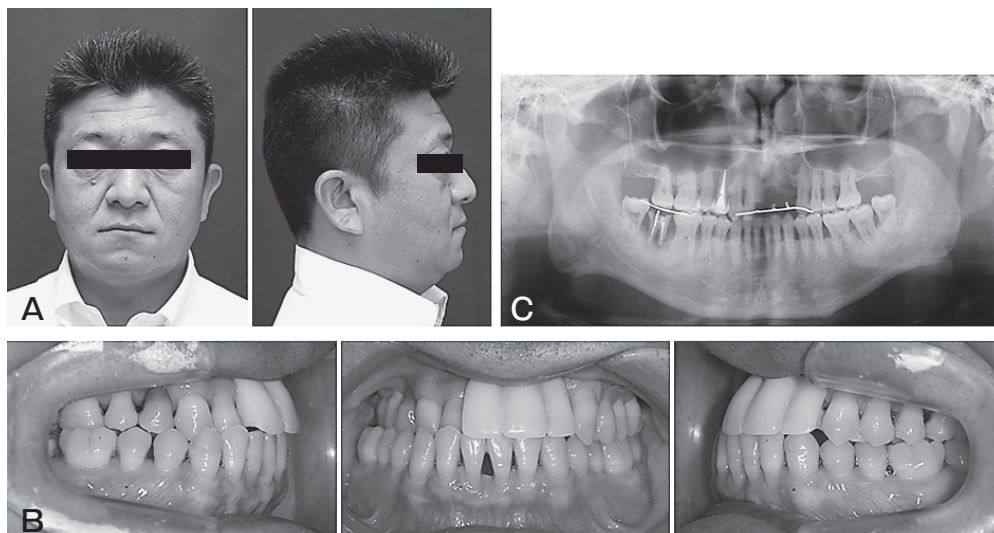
Pretreatment views. A, Facial photographs; B, Intraoral photographs; C, A panoramic radiograph.
